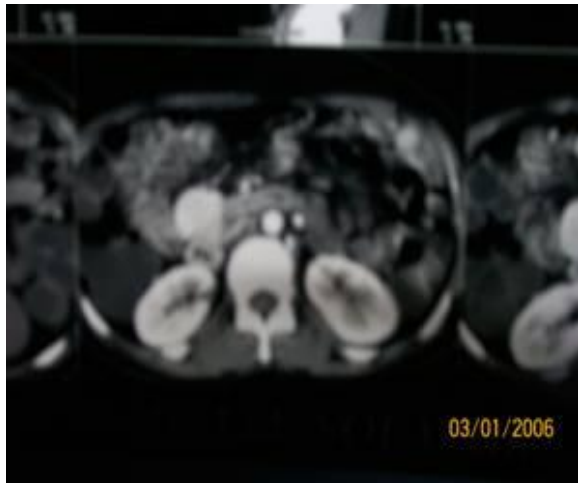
CT scan showing a mass arising from duodenal wall.
